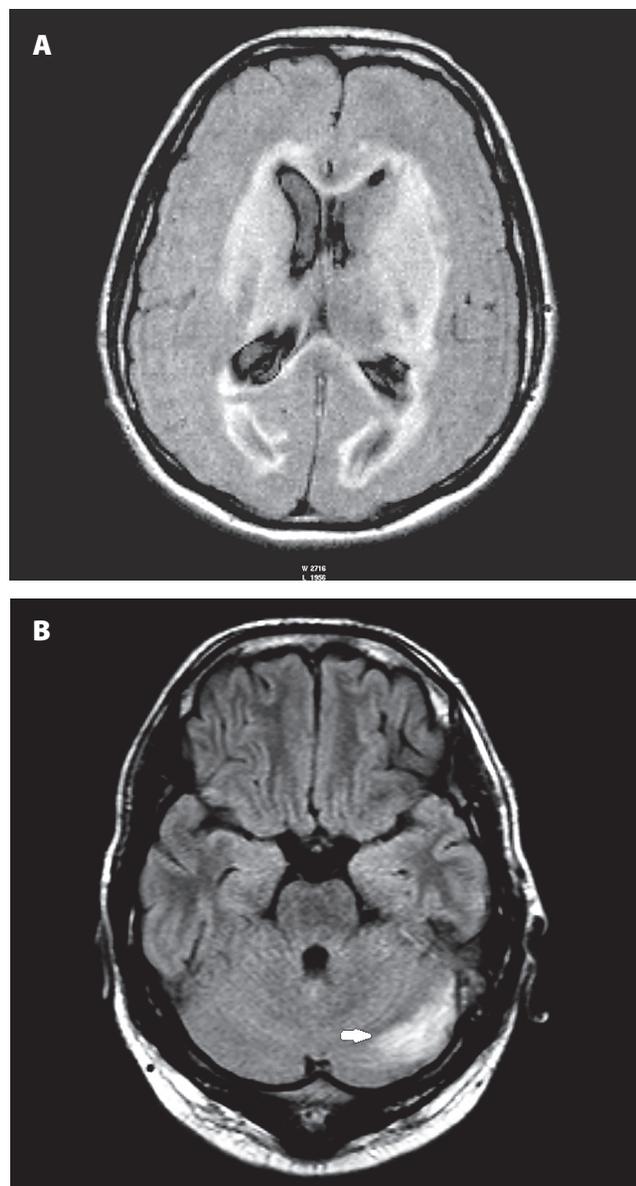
(A). FLAIR sequence, axial plane. Swelling changes in deep brain structures bilaterally in the course of CVST. (B) T1 weighted image, axial plane. Haemorrhagic venous infarct in the left cerebellar hemisphere
